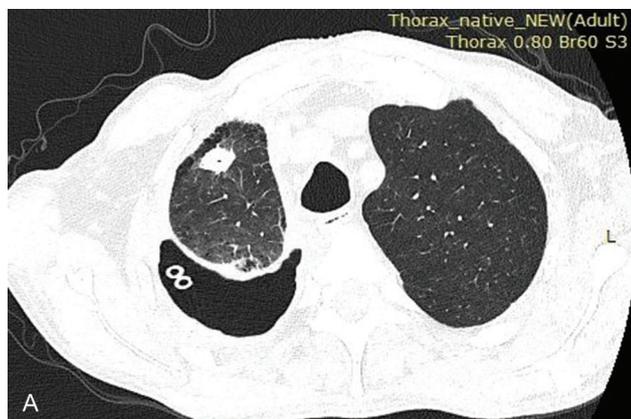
(A, B) CT scan before the thoracotomy showing a nodular lesion in the right upper lobe, an unexpanded right lung, and cylindrical bronchiectasis in the right lower lobe.
